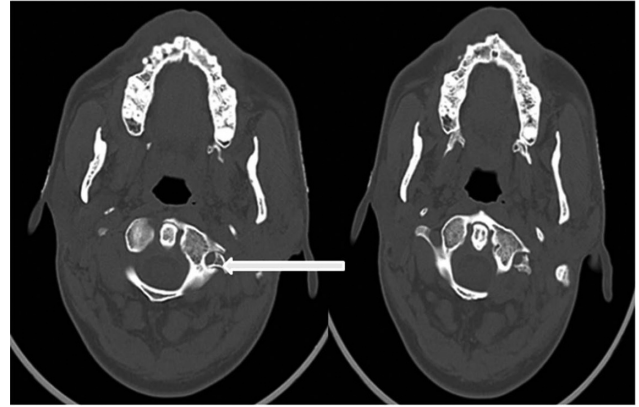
Computed tomography cervical spine axial images showing fracture of Atlas with involvement of transverse process with inward and medial displacement (white arrow).
